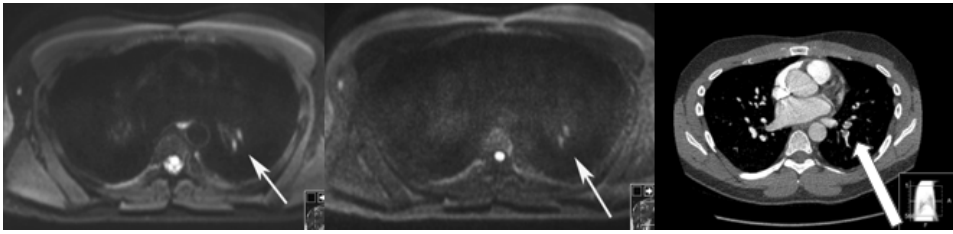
Shows in left and middle, DWI at  $b=50$  and  $b=800$  and right image a corresponding CTPA, two PE in the left lower lobe (white arrows) (Vargas Paris et al.)
